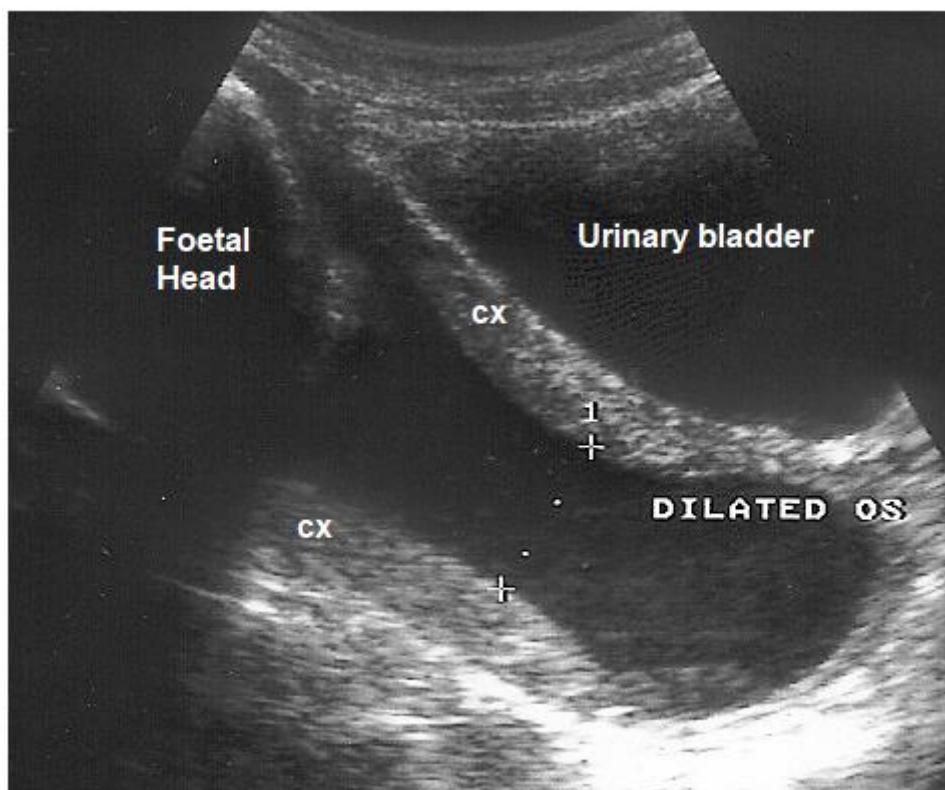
Sonogram of the cervix in 32 weeks pregnancy showing dilated cervical canal / dilated os (> 2 cm) due to cervical incompetence. cx = cervical wall.
